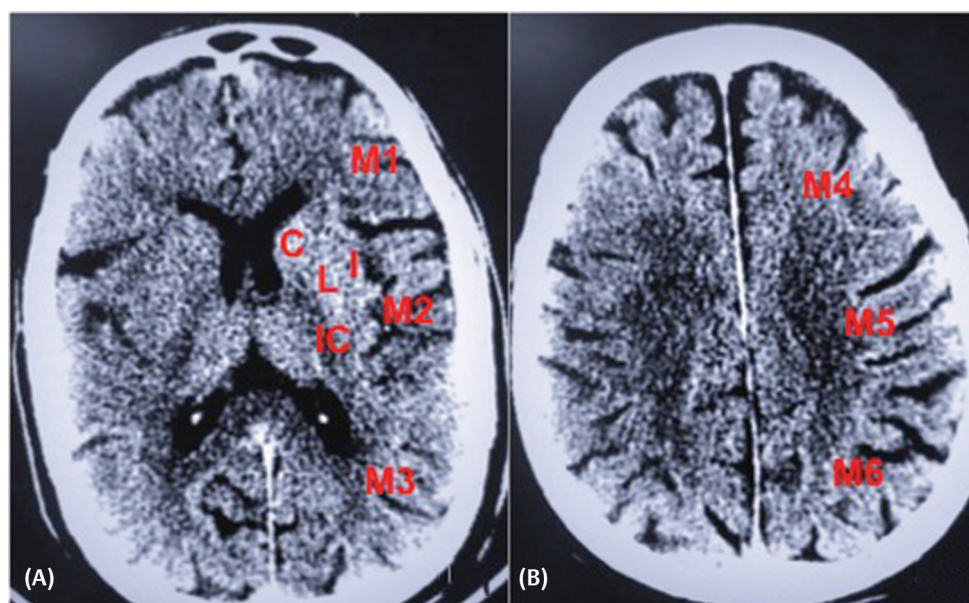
Demonstration of Alberta stroke protocol early CT score (ASPECTS) at basal ganglionic (A) and supraganglionic (B) levels. C, caudate; L, insular cortex; IC, internal capsule; M1-6 respective territorial supply of middle cerebral artery (MCA) territory.
